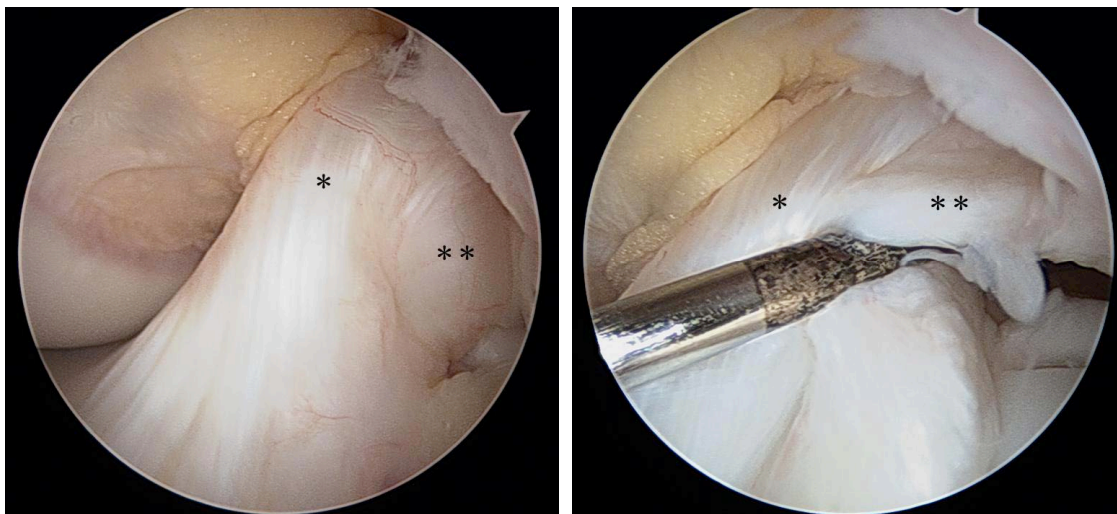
A 14-year-old male with a partially torn ACL proven on arthroscopy. A. MR image: The proton density-weighted oblique sagittal image shows the continuous low signal band of the ACL. B. Arthroscopic images 71 days after the injury. The arthroscopic image shows that the ACL is continuous. *: Anteromedial (AM) bundle. : PL bundle. C. The arthroscopic image shows that the PL bundle is not functional, whereas the AM bundle is functional, with a probe during the anterior drawer stress test. *: AM bundle. : PL bundle.
